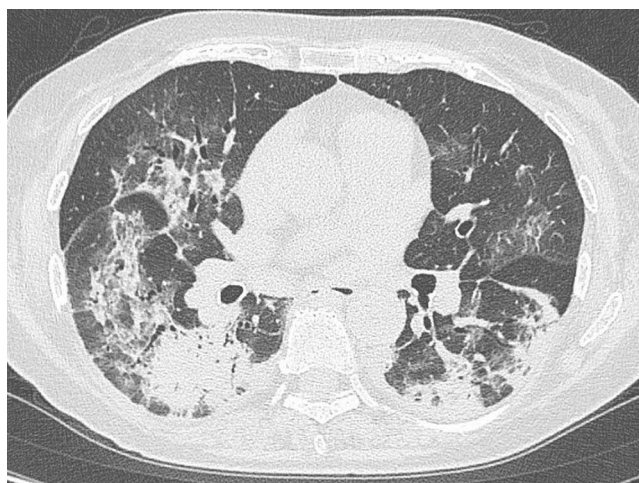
Computed tomography (CT) scan of the chest on admission. The CT scan showed frosted glass shadows and partial dense infiltration in bilateral lungs.
